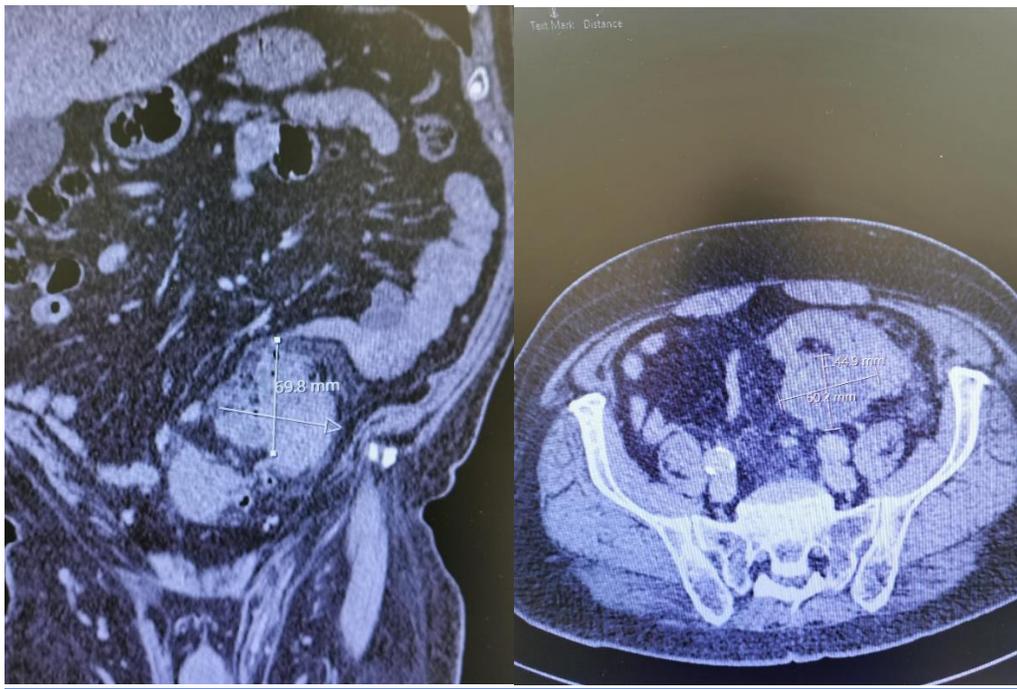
CT scans in axial and cross-sectional views showing a large parasigmoid diverticular collection of 9.1 x 6.8 cm with air locules (inset arrows). After failing to achieve sepsis control by image-guided drainage, laparotomy was performed with emergency Hartmann's procedure.
